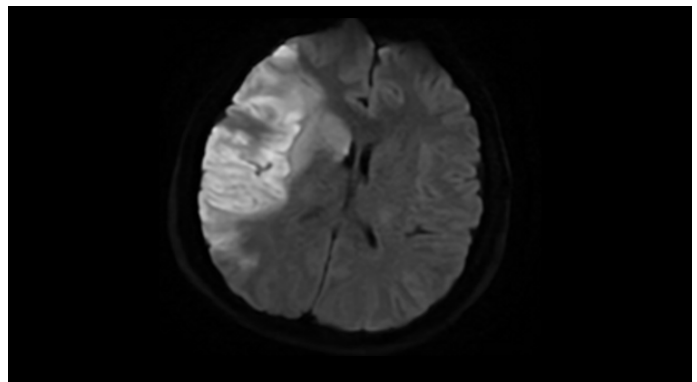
Diffusion MRI axial section showing diffusion restriction in the right MCA irrigation area.
